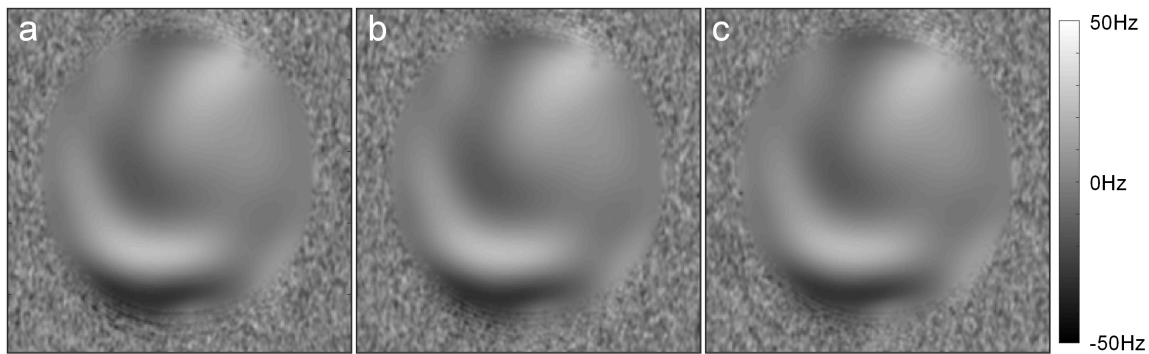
The field maps tested in the three conditions: (a) Power-on, (b) Power-off, (c) absent from MRI.
